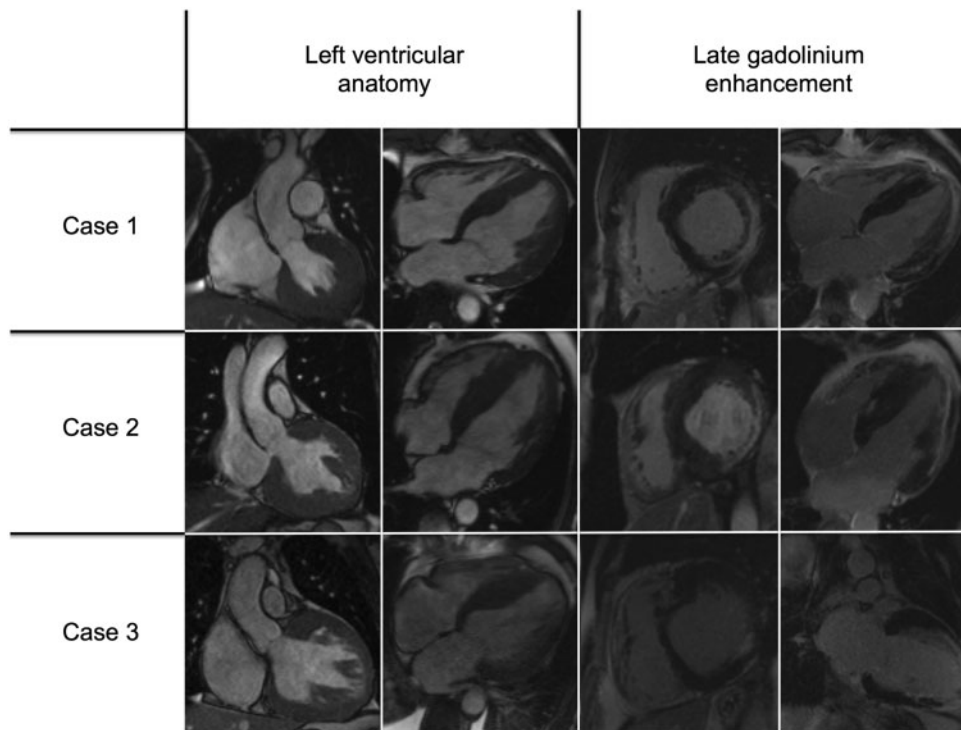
Cardiac magnetic resonance imaging in the three patients, prior to implantable cardioverter-defibrillator implantation.
